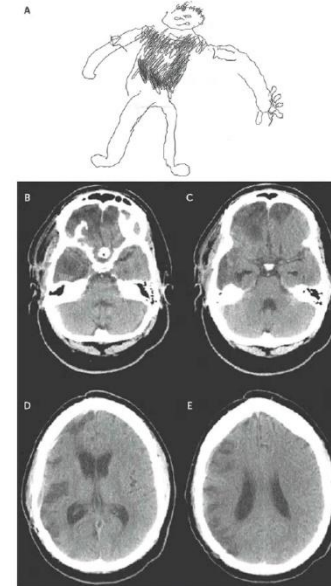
The patient's pictorial representation of his body and the location of the vest. The right and left sides of his body are indicated. [B-E] Axial computed tomography images of the brain in ascending order.
